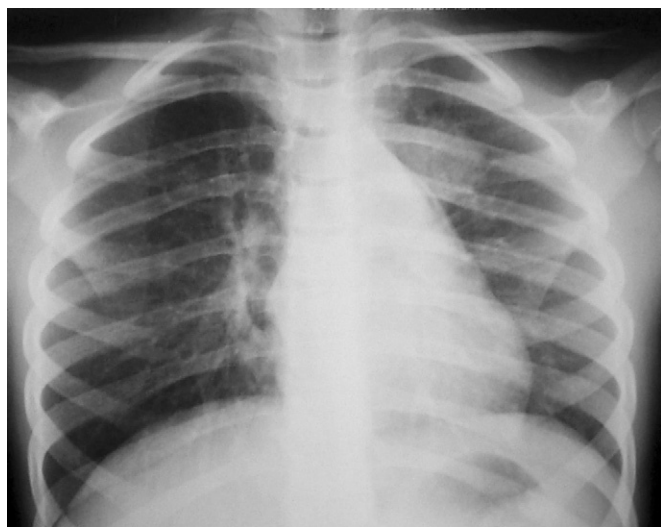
Chest radiograph of an infant with acute bronchiolitis. (Courtesy of Dr. ME Wohl.)
